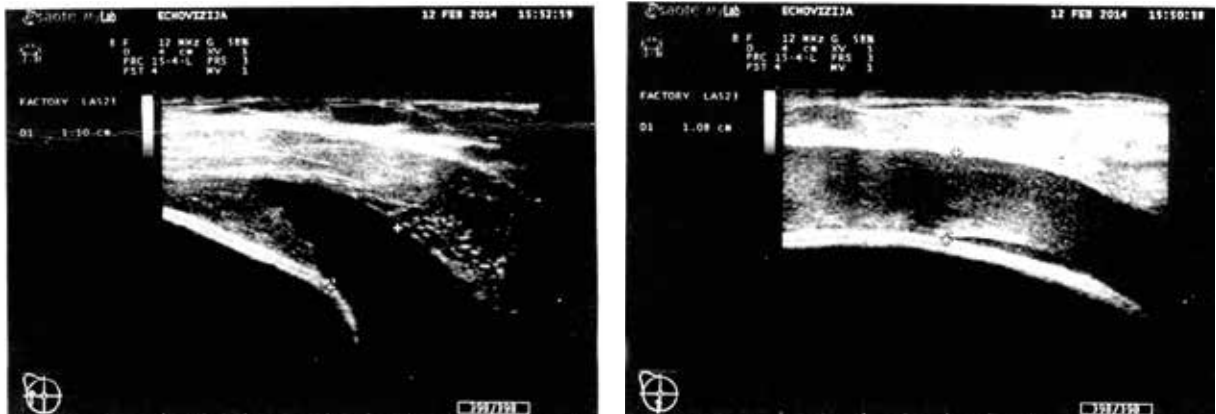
Ultrasound evaluation showing liquid accumulation
